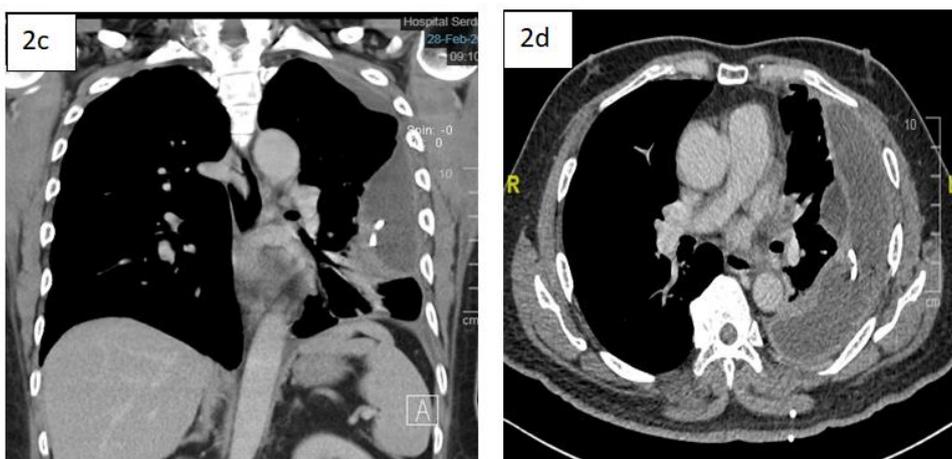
Represents the coronal and axial view of the pre operative CT Thorax. Multiloculated left pleural collection is seen with “split pleura” sign. The effusion is lenticular-shaped and creates an obtuse angles with the chest wall suggestive of empyema thoracis
